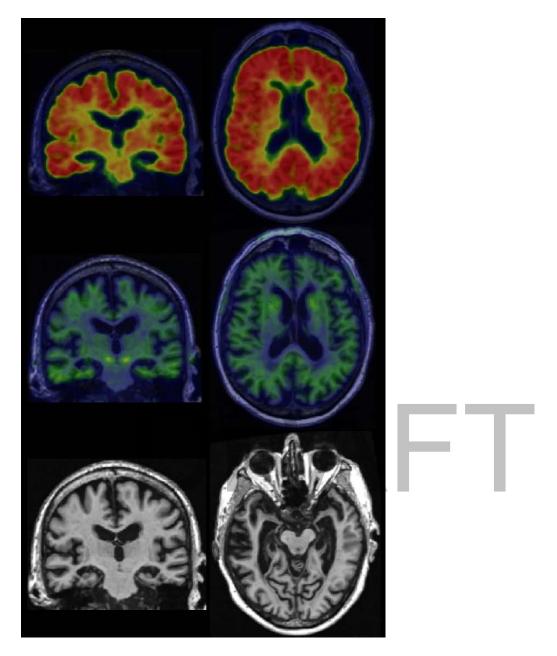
Alzheimer's and concomitant suspected non Alzheimer's pathologic change with dementia. 91 yo, M, severe amnestic dementia. Participant in the Mayo Alzheimers Disease Research Center. Abnormal amyloid PET (a,b), normal tau PET 9 (c,d) and severe medial temporal atrophy on MRI (e,f). The biomarker profile (A+ T- N+) suggests the patient has Alzheimer's pathologic change (A+T-) plus an additional degenerative condition (N+), likely hippocampal sclerosis.
